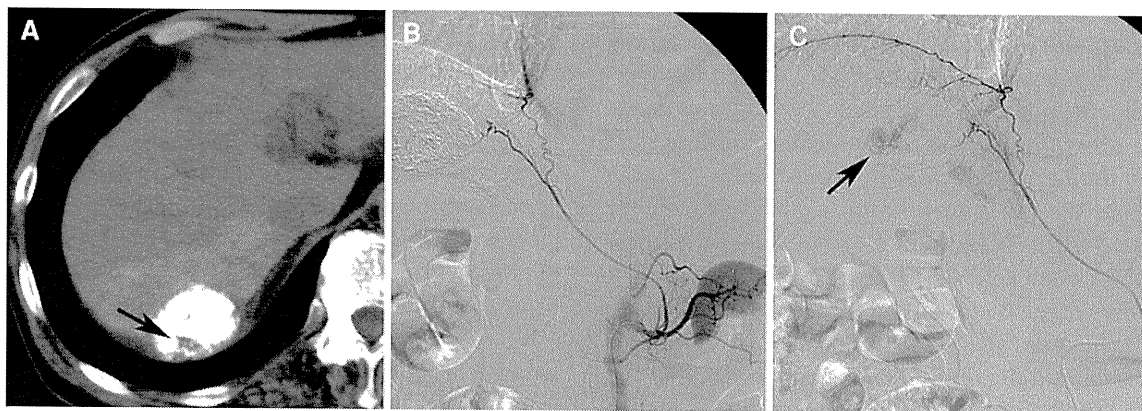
A 68-year-old man with an HCC located in the bare area of the liver. A CT obtained 1 week after chemoembolization through the hepatic arterial branch shows a defect of iodized oil accumulation at the posterior aspect of the tumor (*arrow*). B The right IPA is derived
